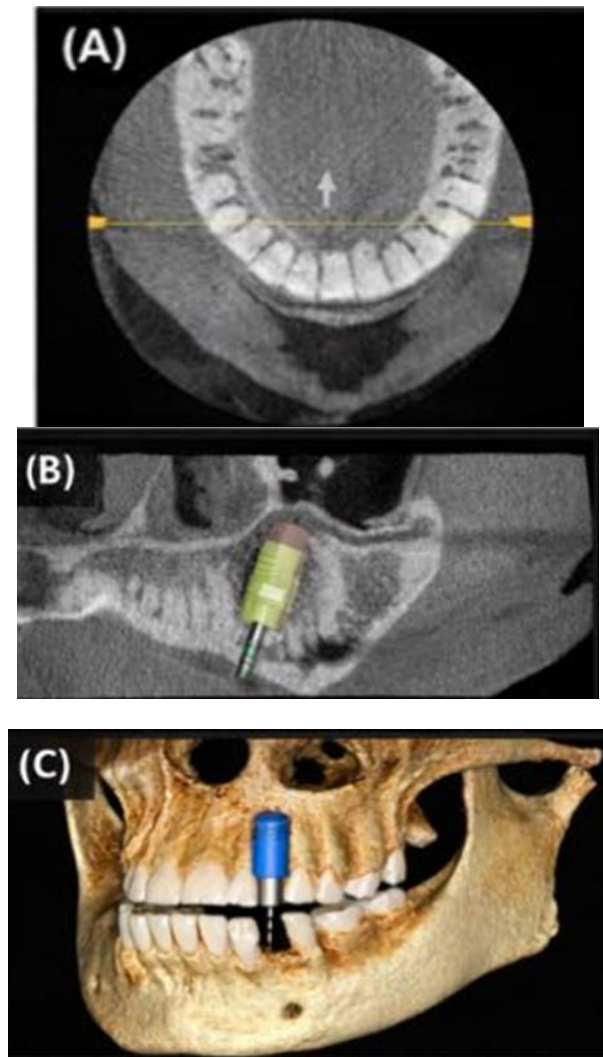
Preoperative CBCT images showing (A) axial view (B) Cross sectional view (C) 3D reconstructed with virtual implant plan
